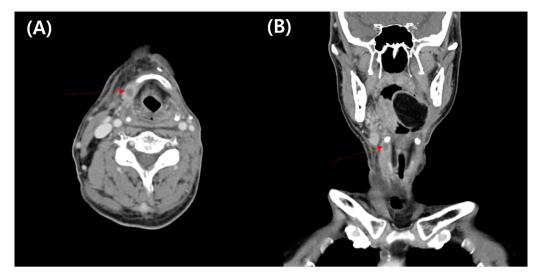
Enhanced CT view of Case 4 patient obtained after the occurrence of local recurrent and distant metastasis reveals enhancing lesion of squamous cell carcinoma at inferior to right hyoid greater horn(red arrows). (A) Axial view, (B) Coronal view. CT, computed tomography.
